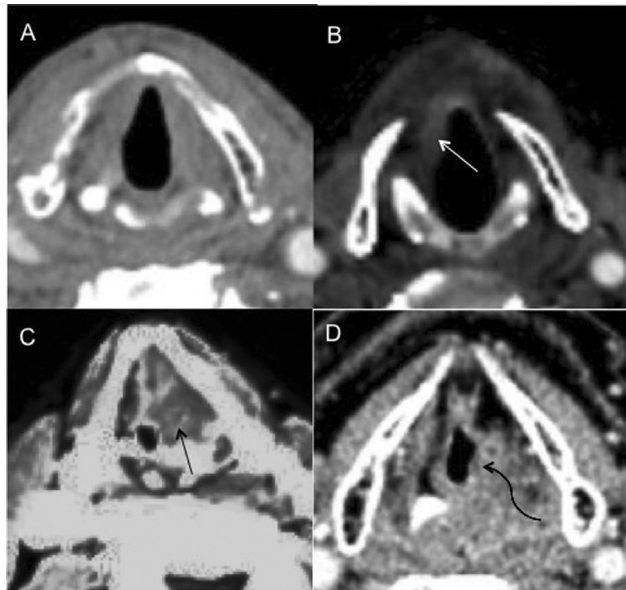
Follow-up computed tomographic scans of postradiotherapy glottic carcinoma. (A) Neck Imaging-Reporting and Data System (NI-RADS 1). (B) NI-RADS 2a—asymmetrical mucosal enhancement on right side anteriorly (*white arrow*). (C) NI-RADS 2b—nonenhancing left-sided soft tissue (*black arrow*). (D) NI-RADS 3—enhancing lesion on left side posteriorly (*curved black arrow*).
